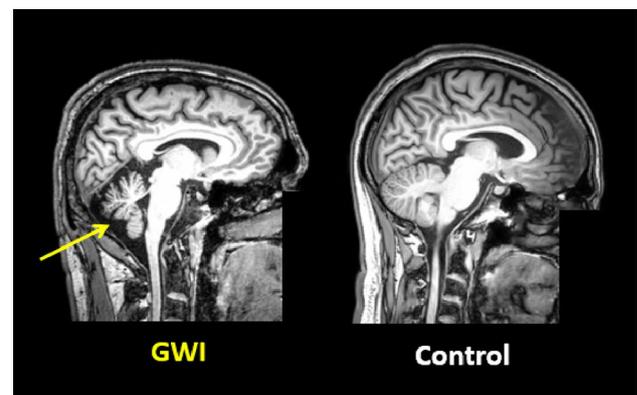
Sagittal T1-weighted MRI images from a level just left of midline, from a participant with GWI and an age- and sex-matched healthy control participant. Note the markedly decreased cerebellar volume (arrow) in the GWI brain
